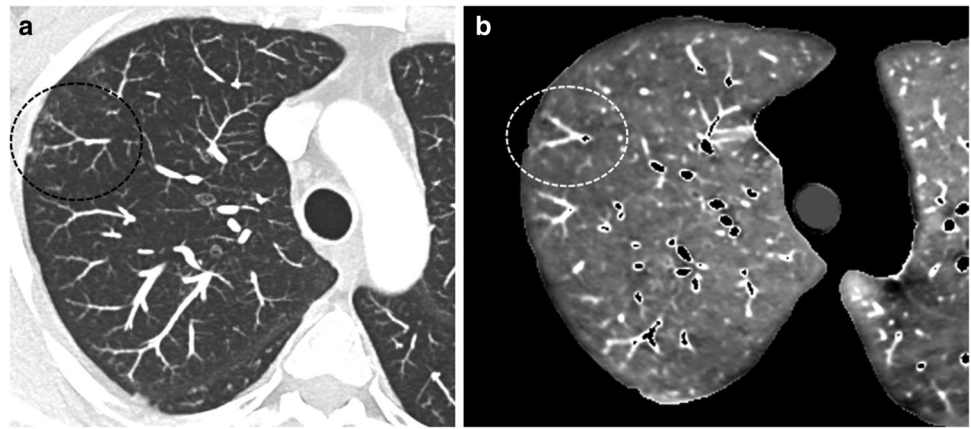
Dual-energy CT angiography obtained in a 60-year-old obese male (BMI: 32.5 kg/m<sup>2</sup>), 24 weeks after COVID-19 pneumonia that had required oxygen supplementation. Lung image obtained at the level of the upper lobes (a) showing the presence of post COVID-19
